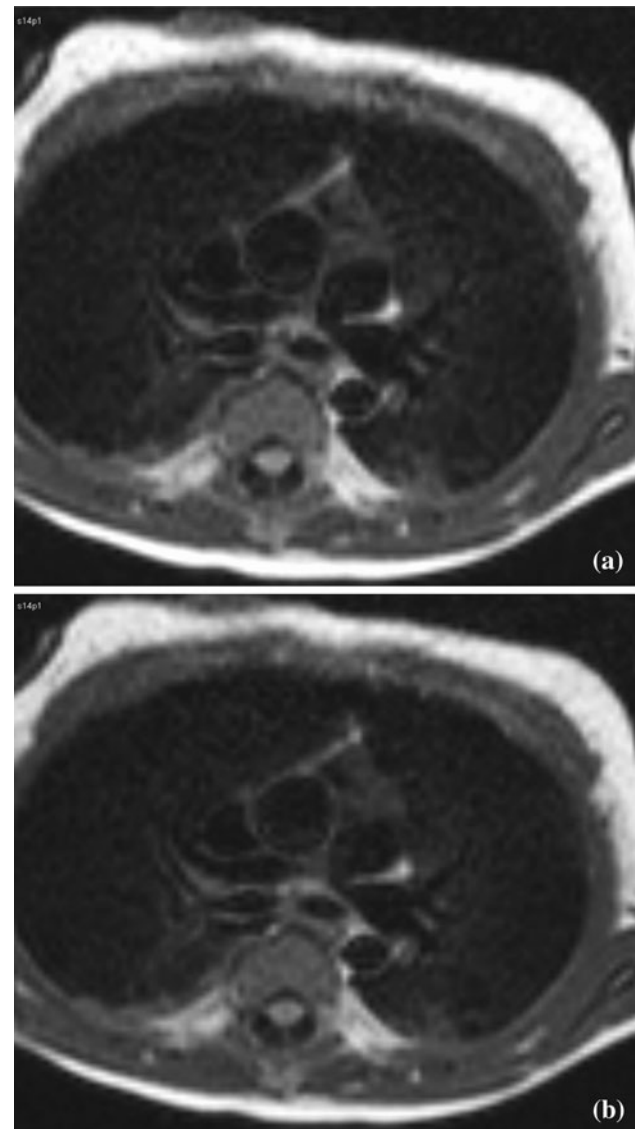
Axial TSE MRI obtained using a Siemens 1.5-T Symphony magnet with a CMV and b HFOV
